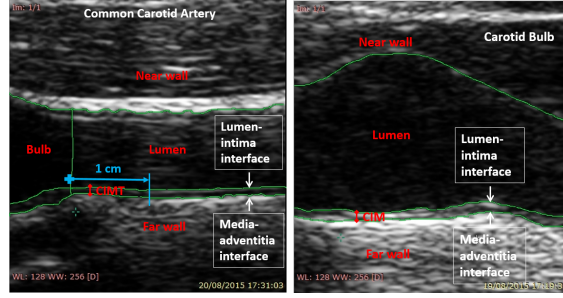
Common Carotid Artery (CCA) (left) and Bulb (right) ultrasound longitudinal images. The different parts of the CA are delimited with green lines. The CIMT is measured approximately 1 cm distal from the carotid Bulb on the far wall in CCA.
